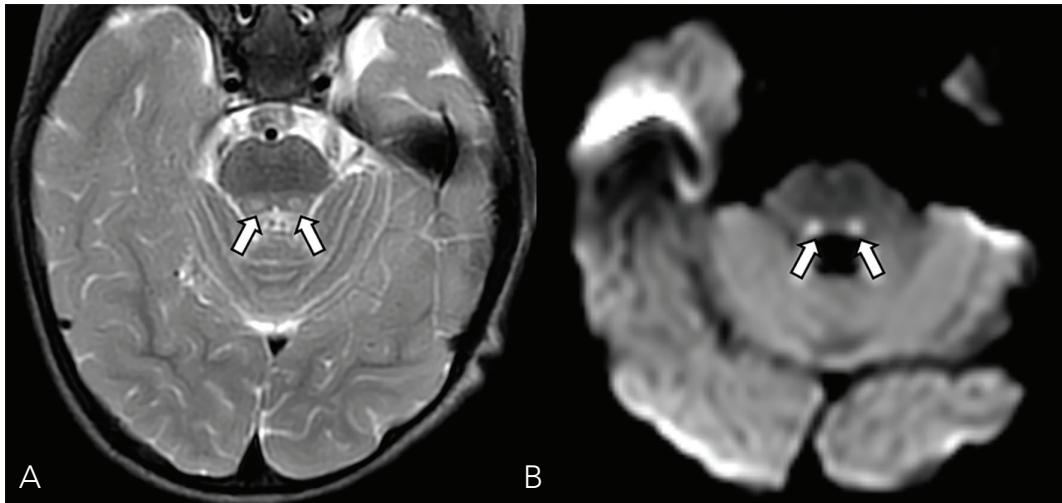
In a 16-month-old male patient followed for mitochondrial disease, central tegmental tract hyperintensity is demonstrated on (A) T2-weighted imaging and (B) diffusion-weighted MRI (arrows)
